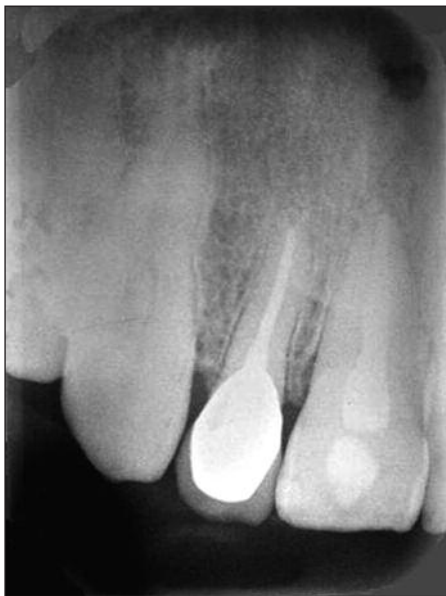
The radiographic image of the tooth after one year.
